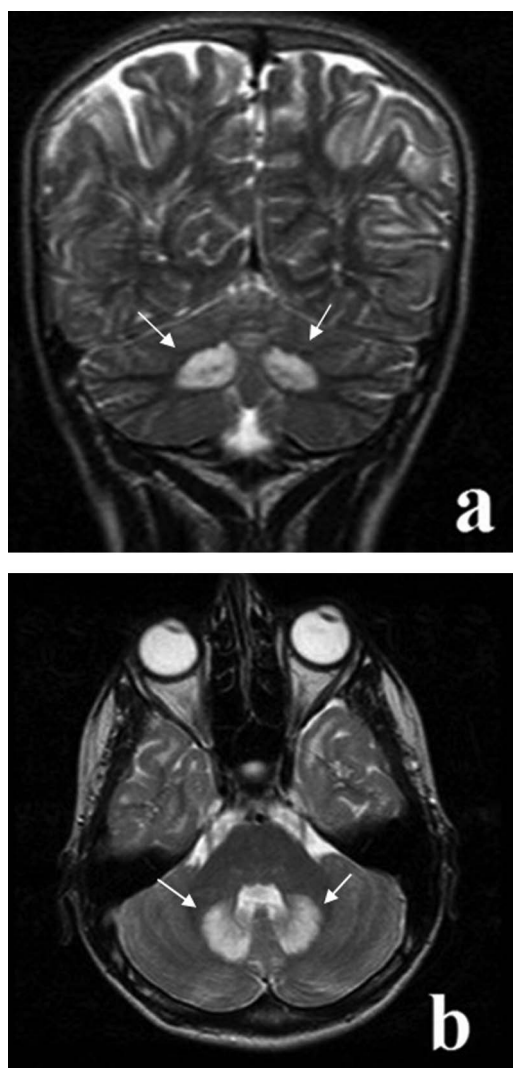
Coronal (A), axial (B) T2-weighted sequences subcortical white matter and bilateral dentate nuclei hyperintense appearance (white arrows).
